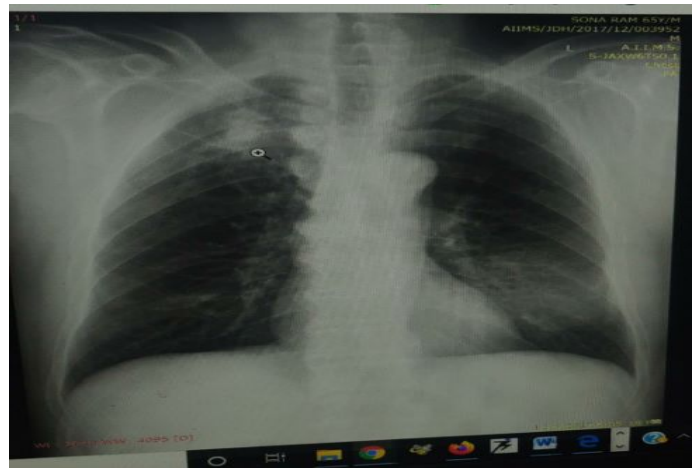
X-ray chest showing suggested haziness in the right upper and left middle zone.
